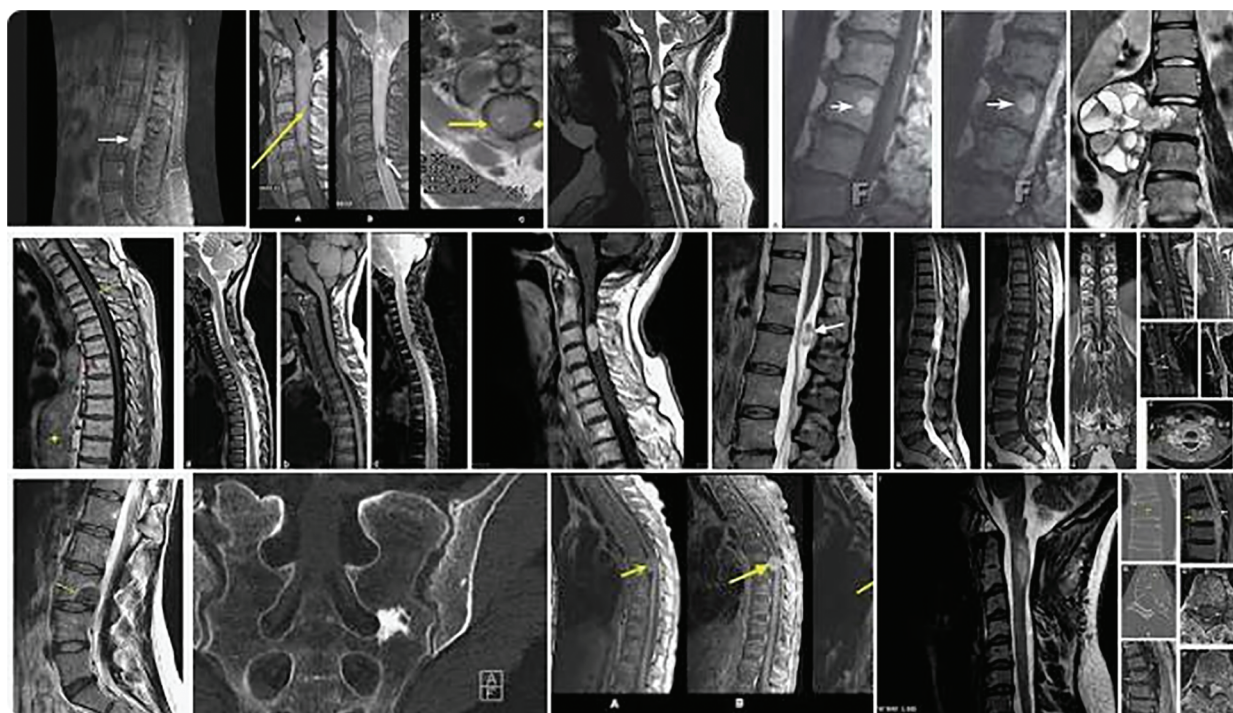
Sample spine MRI images
